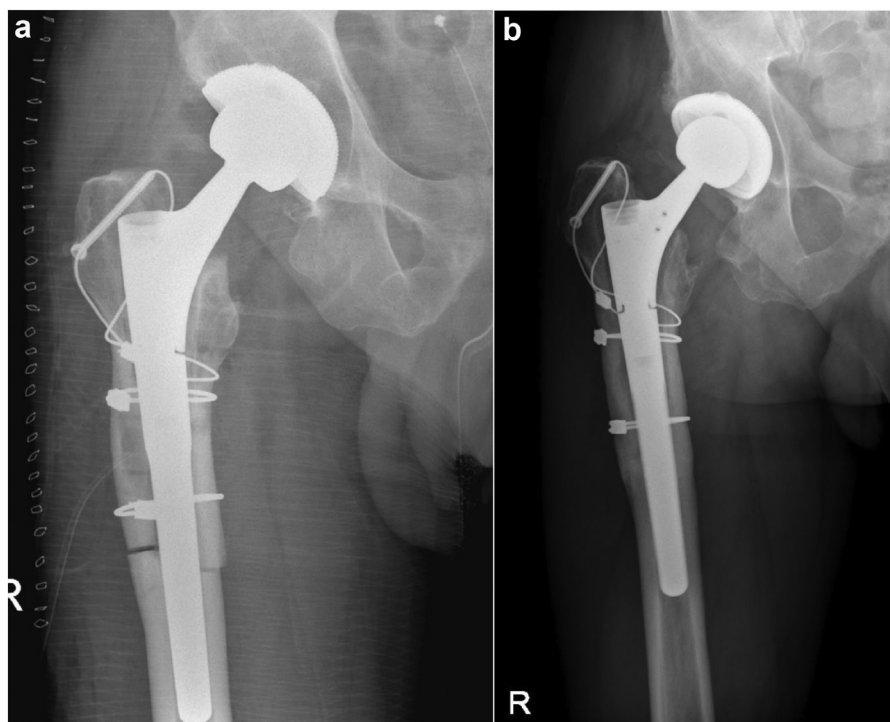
Presence of radiolucencies: radiographs taken postoperatively (a) and at a follow-up visit (b) showing radiolucent lines in zones 1 and 7 according to the study by Gruen et al. [19].
